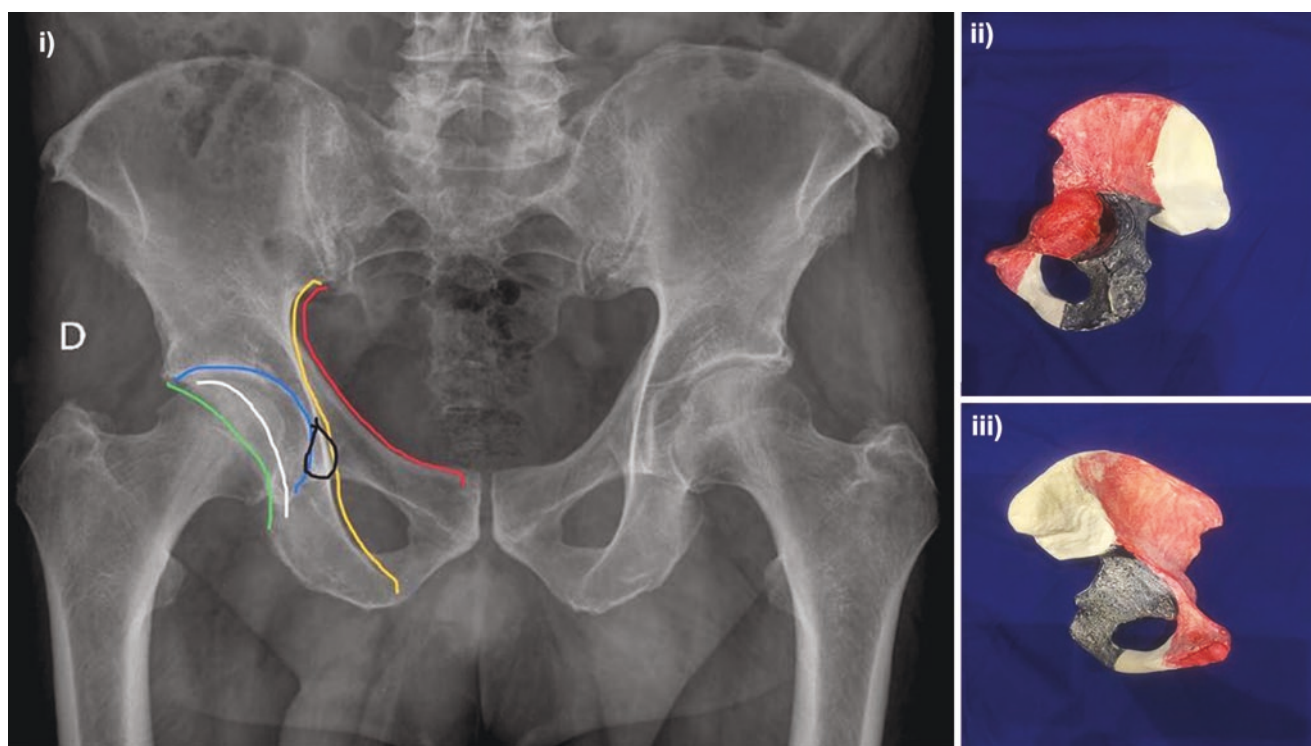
(i) Antero-posterior view of the pelvis. Colour lines represent the following: Red: iliopectineal line. Yellow: ilioischial line. Green: Posterior wall. White: Anterior wall. Blue: dome of the acetabulum. Black: Radiographic teardrop. (ii) Obturator oblique view; (iii)
